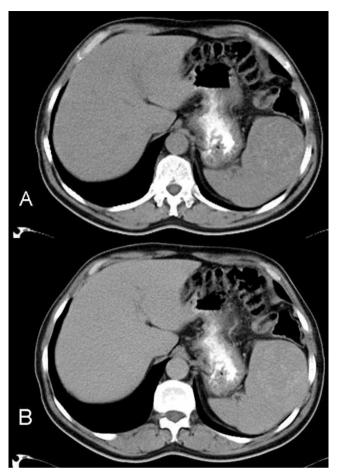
Unenhanced computed tomography scans (A) revealing a heterogeneous intrasplenic area with indistinct margins and mottled densities. Following intravenous contrast injection (B) a slight peripheral enhancement was noted.
